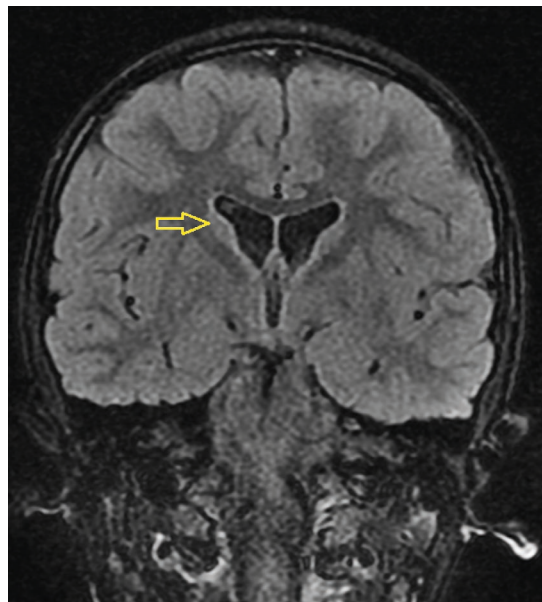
Striatal atrophy on brain magnetic resonance imaging.
